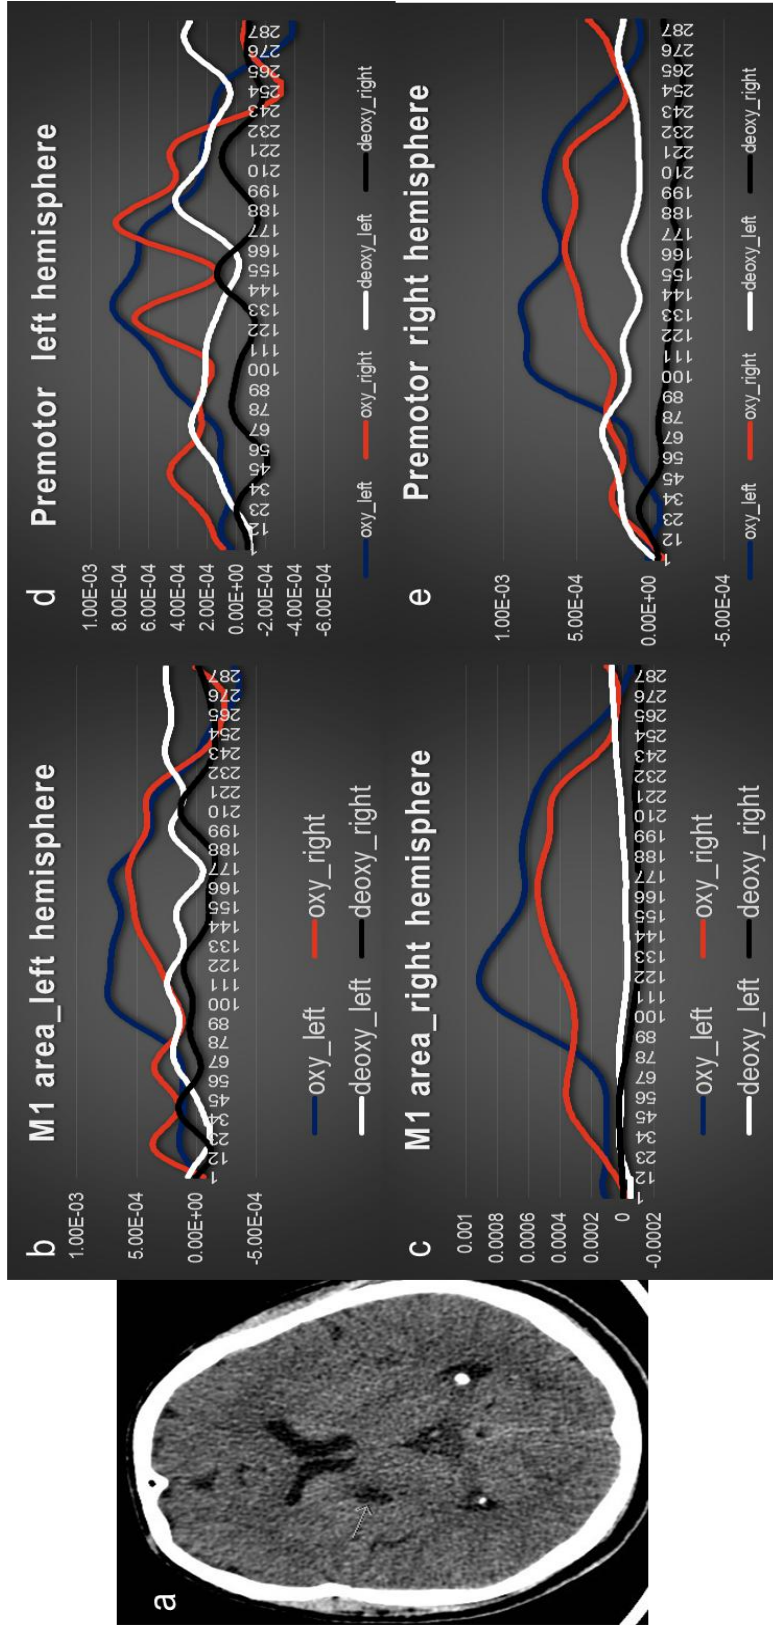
shows the MRI of the subject with right hemisphere stroke affected areas indicated in hypo intensity and arrow indicate the location b) and c) show the response from the primary motor cortex channels for both hemisphere. d) and e) show the response from the pre-motor and supplementary cortex channels for both hemisphere.
